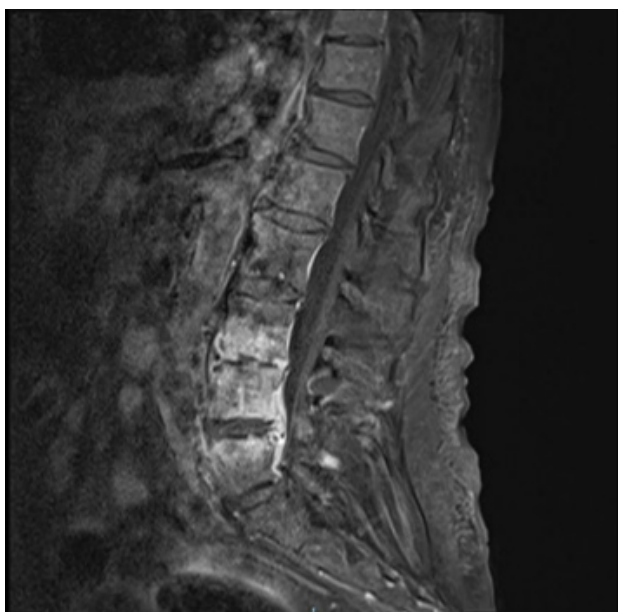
MRI with contrast: Phlegmonous inflammatory changes in L3-L4 and L4-L5 suggestive of spondylodiscitis.
